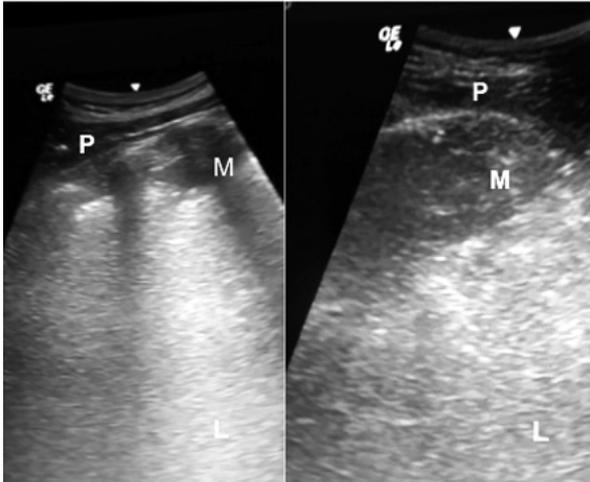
Transthoracic ultrasound revealed infiltration of the fourth rib appearing as a hypoechoic mass and replacing the normal echogenicity of the rib. Definition of abbreviations: P (Pleura), M (Mass), L (Lung)
